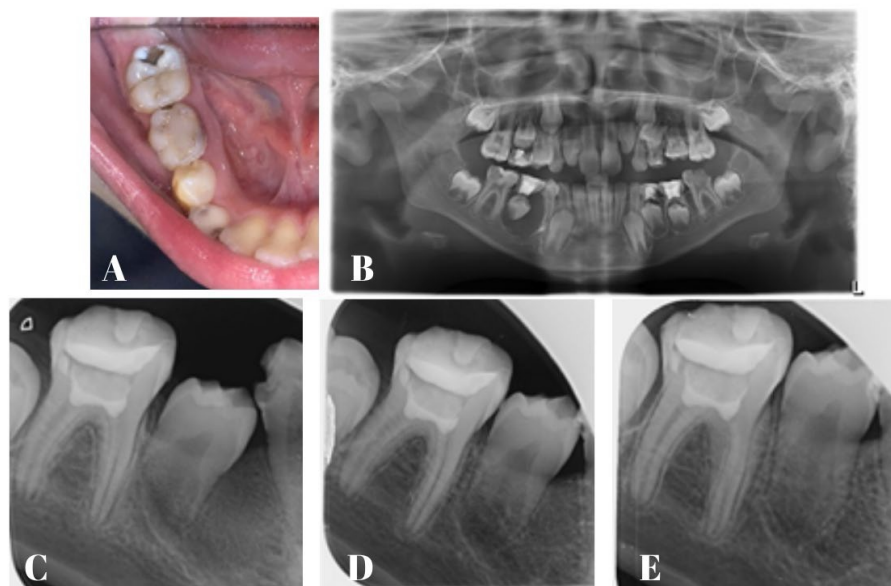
A: Preoperative photograph showing tooth 36 with deep dentin caries, B: Preoperative radiograph of tooth 36, C-D-E: 6,12 and 18 months follow-up.
